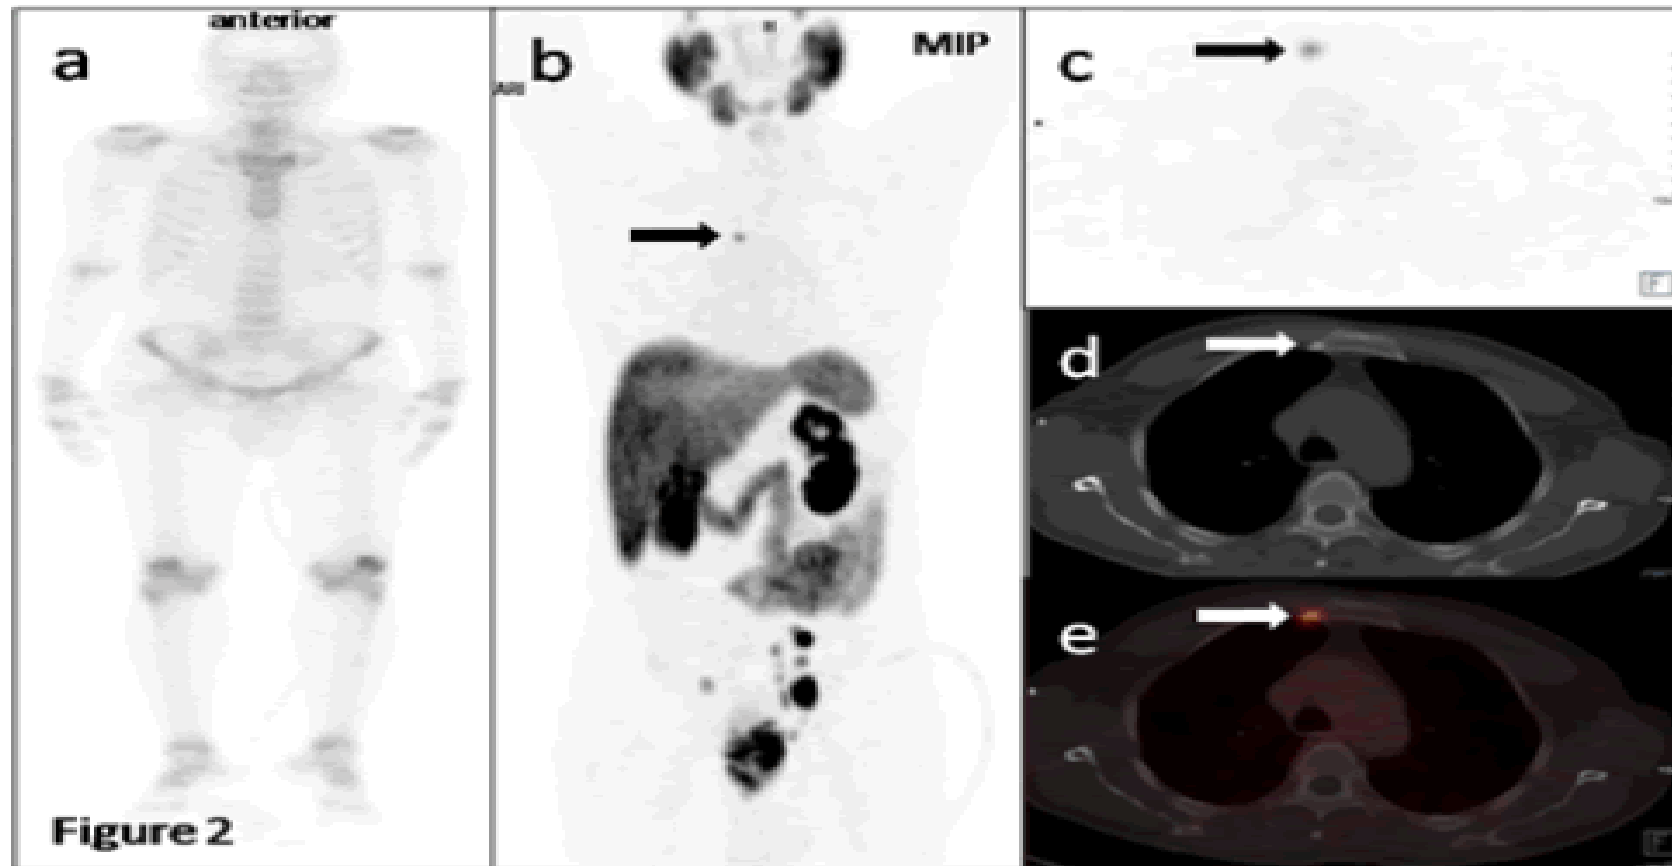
62 Years male with adenocarcinoma prostate, gleason score 5+4, PSA 17.5 ng/ml underwent MDP bone scan (image a) and 68GaPSMA PET-CT (image b, c, d, e). MDP bone scan was reported normal while PSMA PET-CT showed locally infiltrating prostate lesion with pelvic lymphnodes and a solitary bony lesion in sternum (block arrows).
